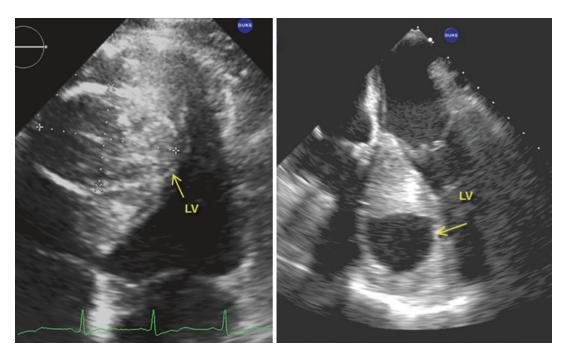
The apical four chamber view in the left panel shows an oval, cystic mass in the mid interventricular septum measuring about 3.5×-6 cm taken from a 53 y.o. man with chronic wasting and debilitation. The transesophageal four-chamber view in the right panel more
